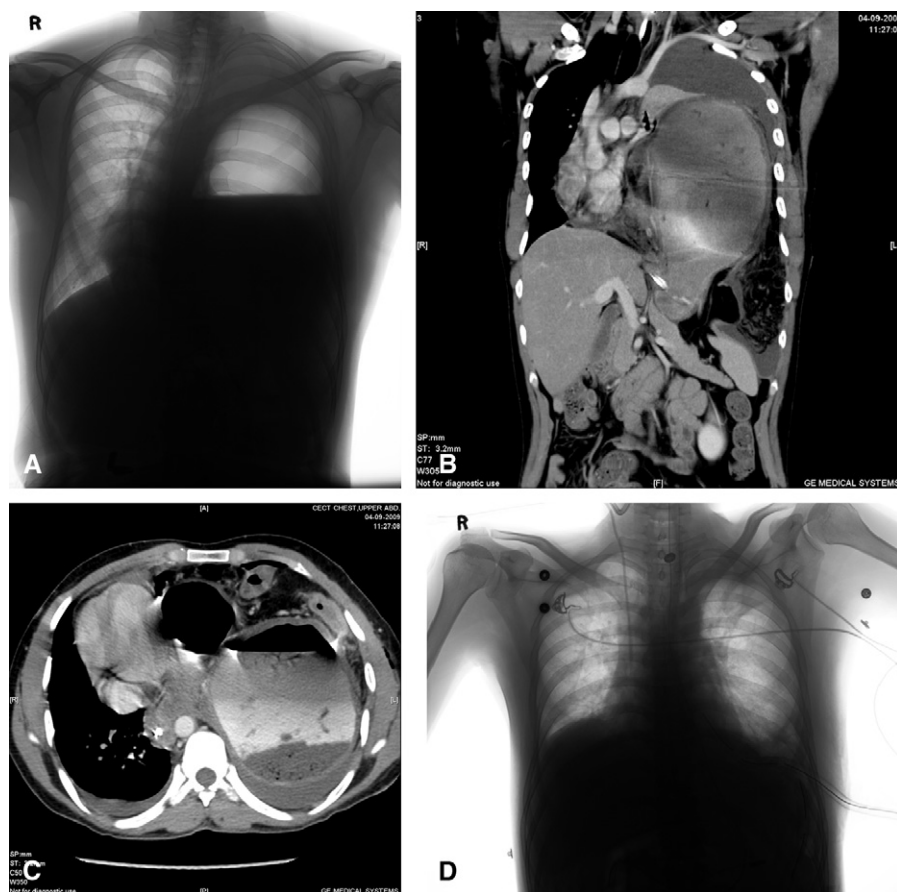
A, Chest x-ray showing the picture mimicking tension hydropneumothorax. B, C, 64-slice computed tomography scan of the chest and upper abdomen showing the herniation of the stomach and left lobe of the liver. D, Chest x-ray after surgery showing normal position of stomach and expanded left lung.
